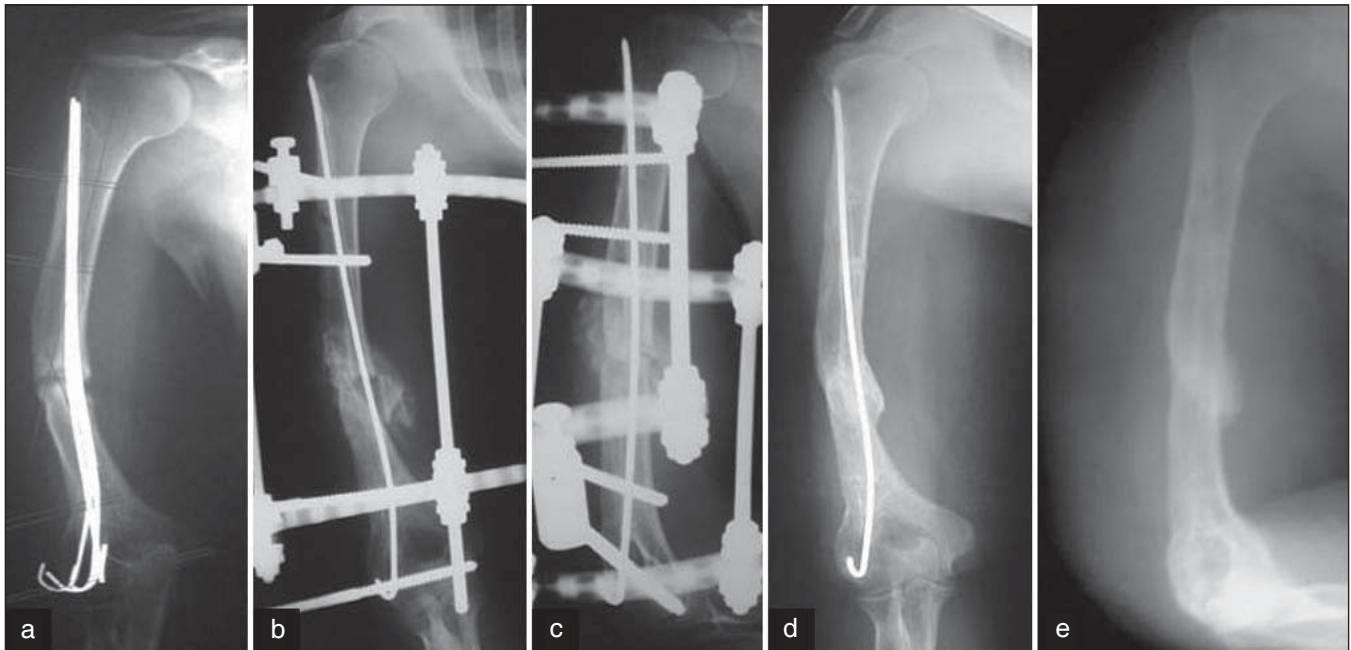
(a) Preoperative radiographs of a nonunited fracture of the middle third of the humerus in a 46-year-old female patient previously treated surgically with intramedullary fixation and bone graft. (b, c) Postoperative radiographs showing exchange of the intramedullary rod, with bone graft and application of a modified Ilizarov external fixator. (d, e) Follow-up radiographs showing sound union
